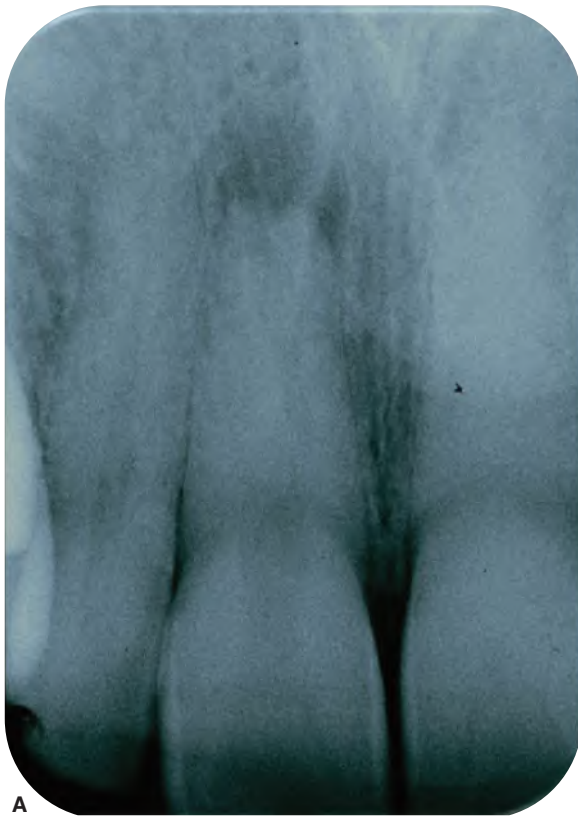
A-D. Radiographically calcified root canal system in a tooth with periapical pathosis that was difficult to negotiate.
